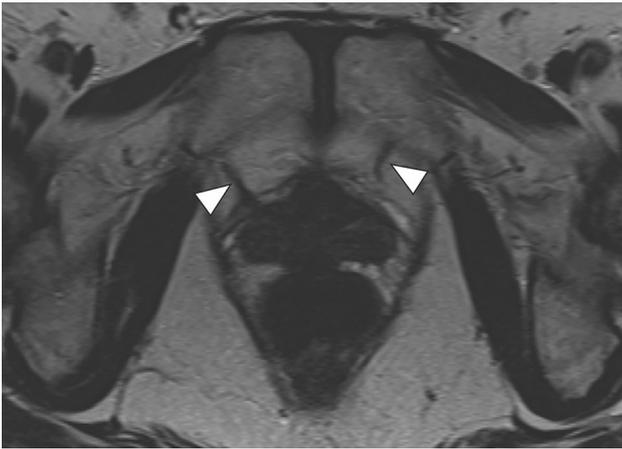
Normal appearance of a midurethral sling. Axial T2-weighted image demonstrates thin hypointense bands extending from the urethra to the pubic bone (arrowheads), compatible with a synthetic sling
